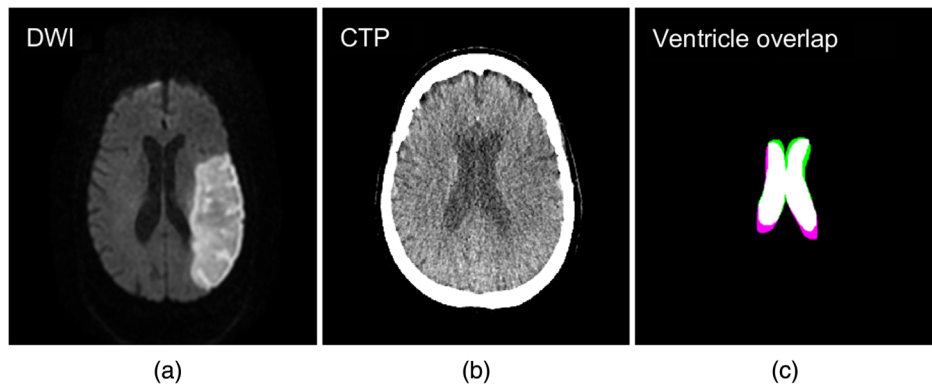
(a) DWI and (b) CTP following image registration of the two volumes. The degree of ventricle overlap is indicated in (c) with white, green, and pink regions indicating overlapping, CTP, and DWI infarct, respectively.
